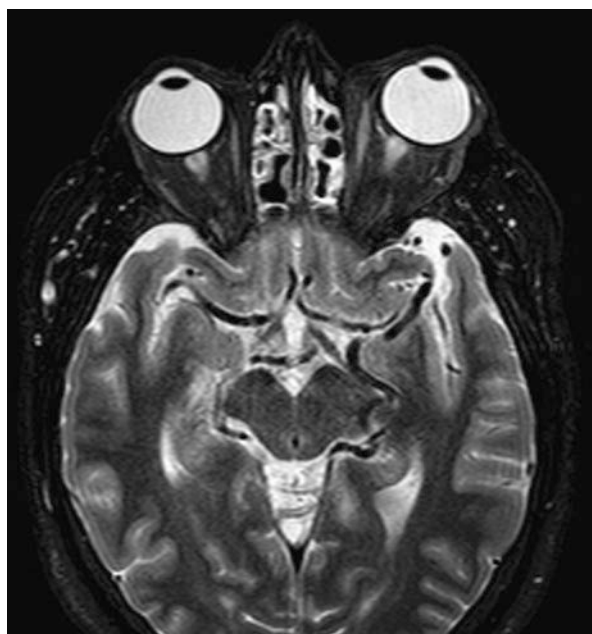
Axial T2 weighted MRI of orbit showing enlargement of the rectus muscles on the left side, an axial proptosis and enlarged veins within the left temporal lobe, extending back to the brainstem
